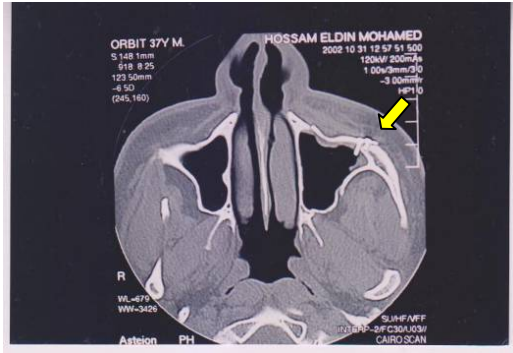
picture showing postoperative CT of case no.3
